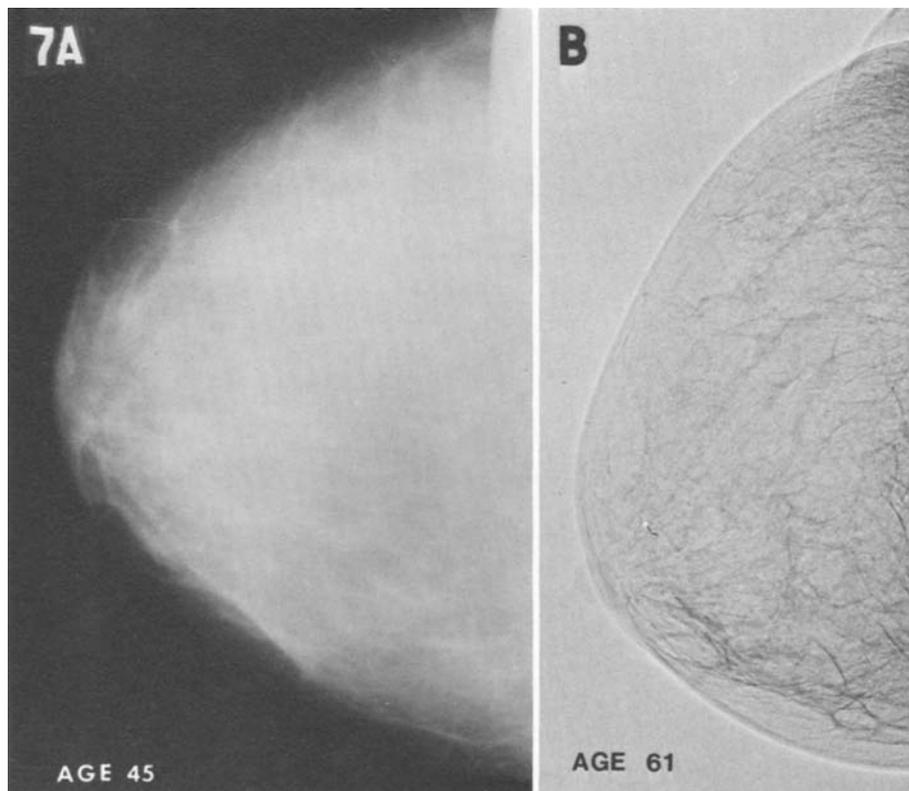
Radiographs taken 16 years apart. Initially the breast is quite dense, with some suggestion of a cord-like pattern in the subareolar area, indicating a P1 classification; the subsequent examination shows that this is correct.
